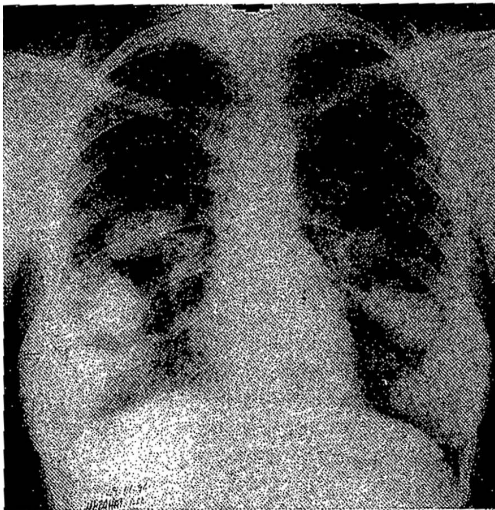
X-ray showing variable sized nodular opacities in the lower and middle zones of both lungs before therapy.
